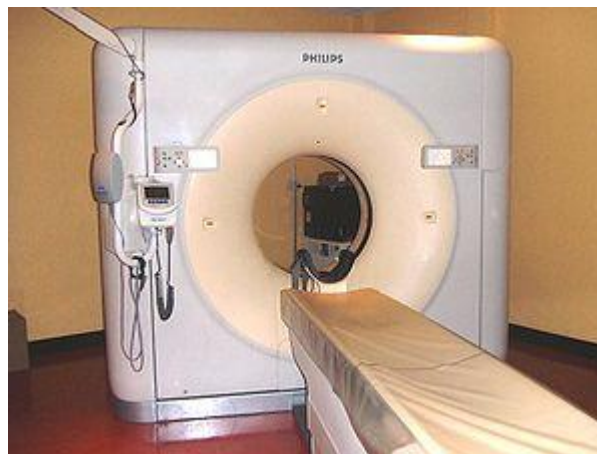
Computer Tomography (CT scan) equipment
